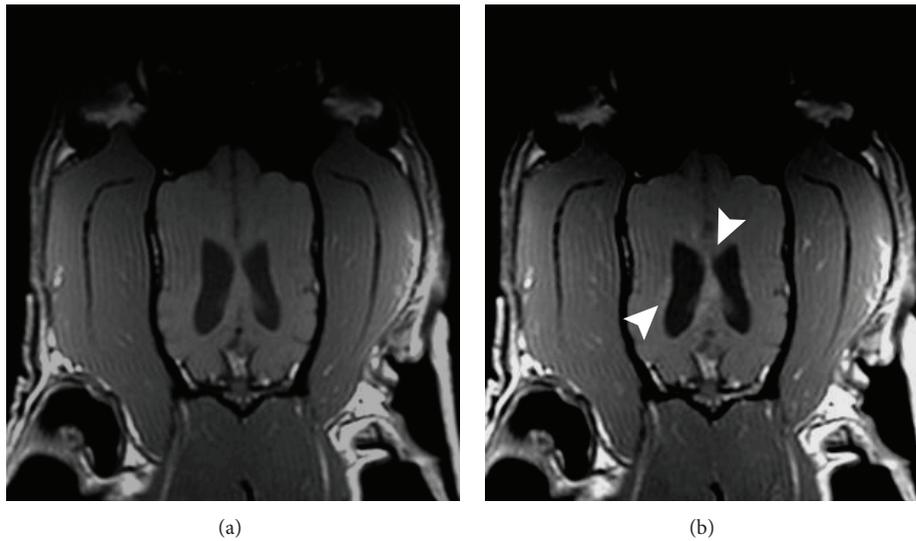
T1-weighted dorsal pulse sequences before (a) and after contrast (b), at the level of the lateral ventricles. (a) The T1-weighted precontrast images were unremarkable. (b) On the T1-weighted postcontrast sequence, multiple ill-defined mildly enhancing lesions were visible within the right frontal lobe, temporal lobe, and *corpus callosum* and surrounding the lateral ventricles (solid arrowheads).
